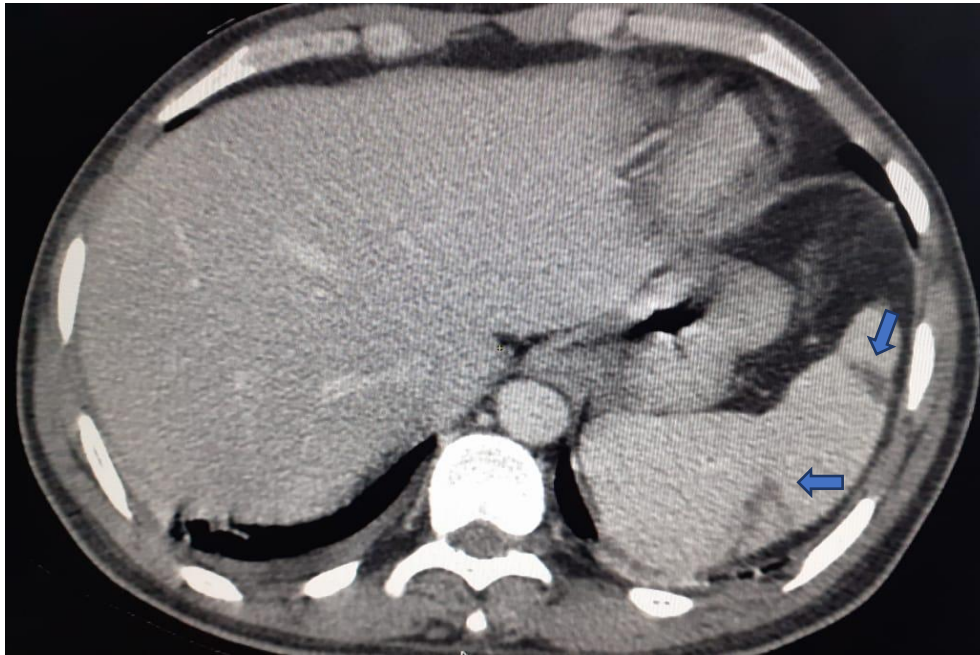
thoraco-abdomino-pelvic CT showing splenic infarcts
